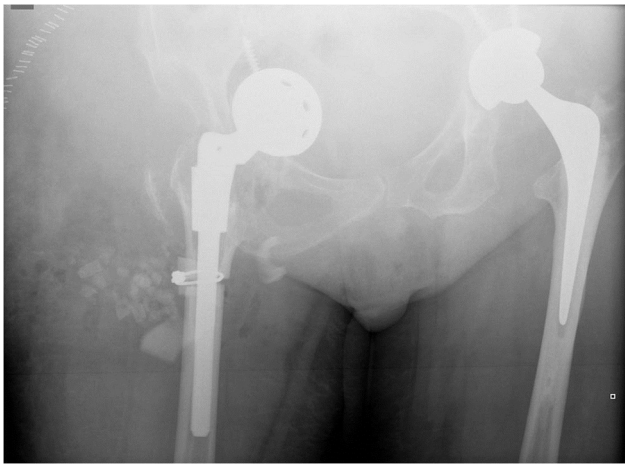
AP radiograph showing the displaced hip prosthesis into the pelvic cavity.
